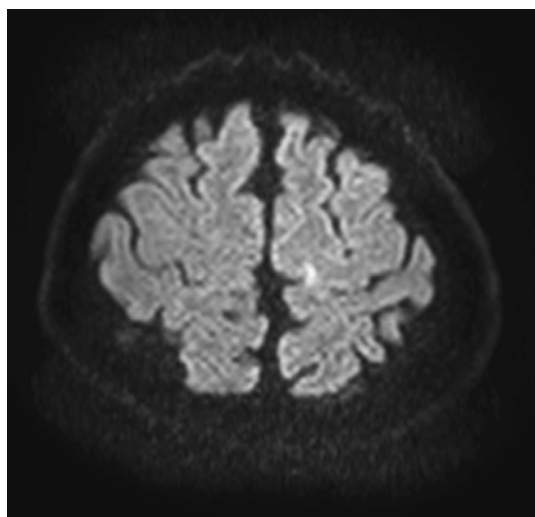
Brain magnetic resonance imaging on the first hospital day. The diffusion weighted imaging (DWI) showed high-signal lesion in the anterior cerebral artery region.
